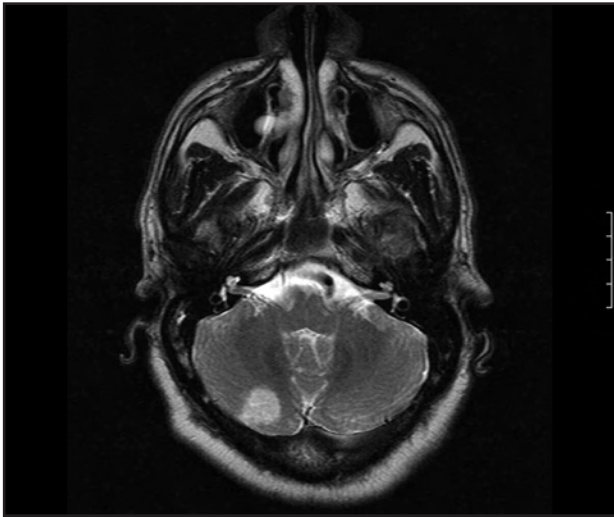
MRI scan showing ischemia in the right cerebellum.
